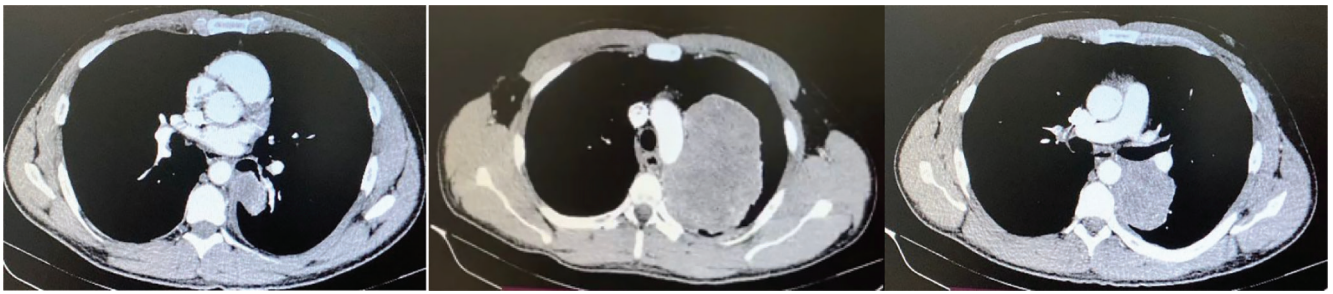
Chest CT scan. A large mass in the left upper lobe which did not have a plane of clivage from arch and descending aorta, as well as from left the pulmonary artery.
